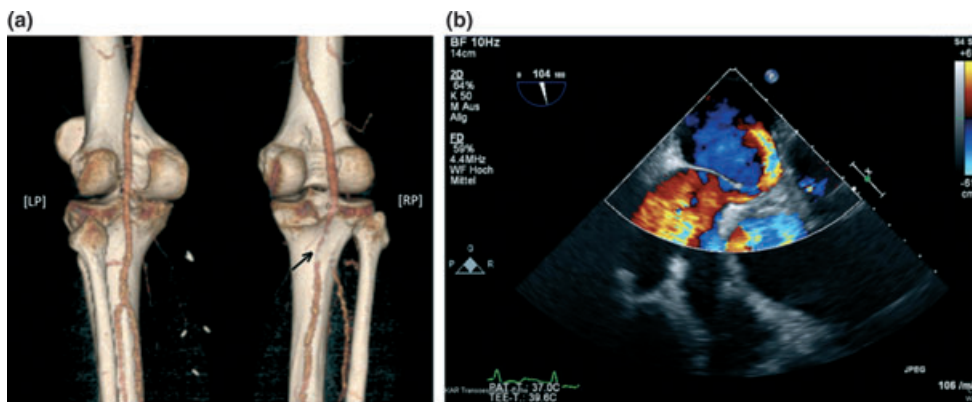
Findings supporting the putative paradox embolic disease in the patient. (a) CT-Angio depicting a thrombus in the right popliteal artery (→). (b) Transesophageal echocardiogram with colour-coded duplex demonstrating a patent foramen ovale with a spontaneous right-to-left atrial shunt.
